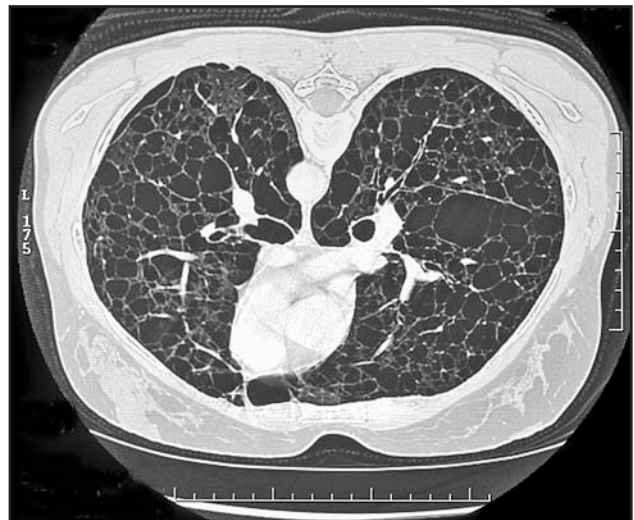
CT scan of a patient with severe LAM. The lung parenchyma is almost completely replaced by cysts.
